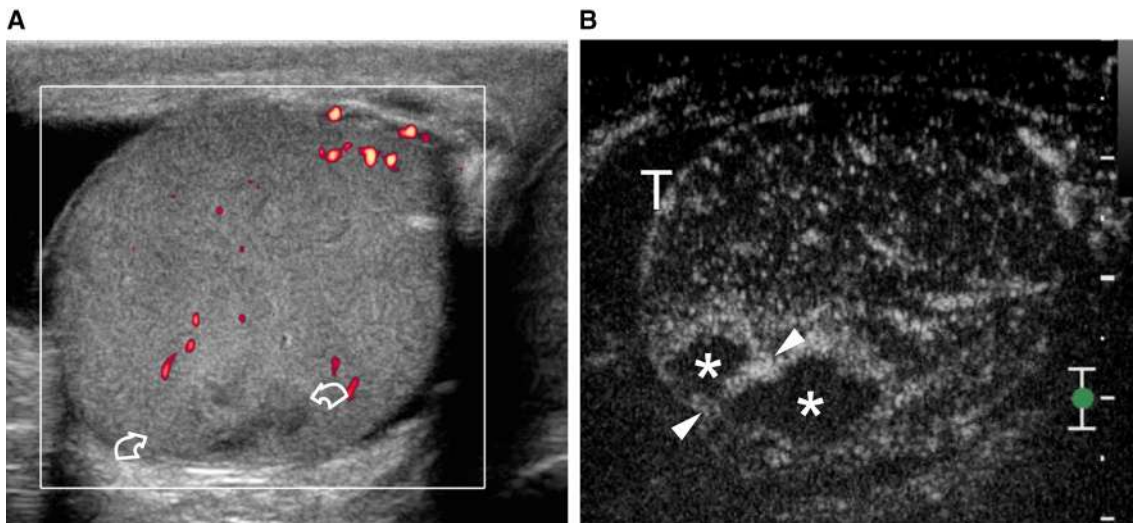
Patient with longstanding high-degree testicular torsion investigated with multiparametric US. A Color Doppler US shows avascular, hypoechoic inhomogenous left testis
